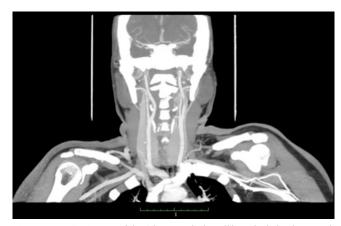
CTA carotid. Observed the dilated right internal jugular vein, with no demonstrated fistula seen with the carotid (no contrast flow seen in the right IJV)
